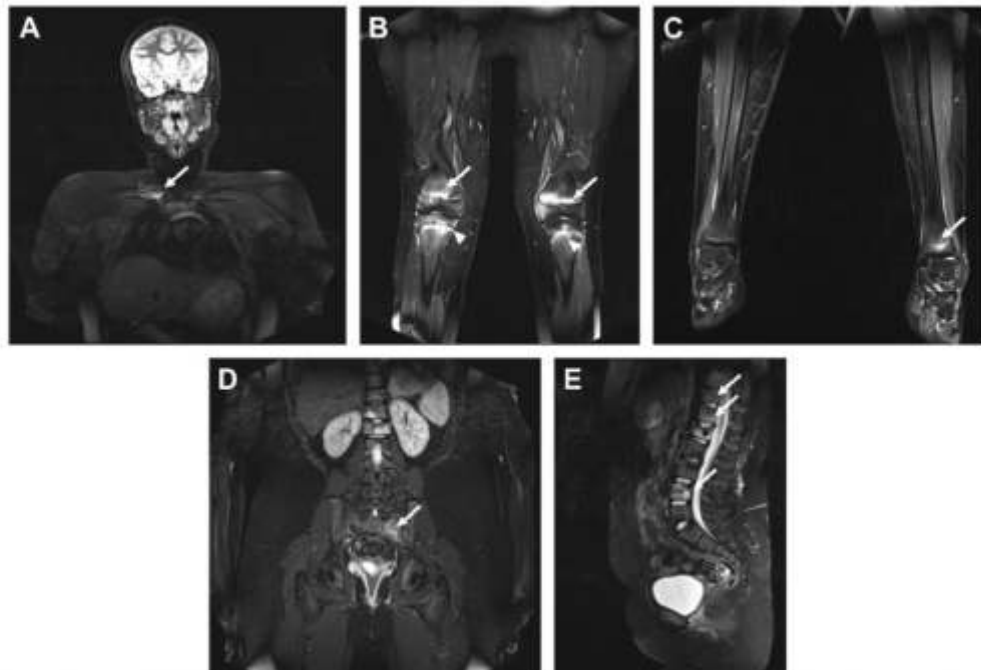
Whole body MRI in a 12-year-old girl with chronic recurrent multifocal osteomyelitis (CRMO). T2 TIRM images show bone marrow oedema of the sternal end of the right clavicle with oedema of the surrounding tissues (A), bone marrow oedema of the distal femoral epiphysis, proximal tibial epiphysis, and to a minor extent in a knee joint epiphyses bilaterally (B), bone marrow edema in the left distal tibial epiphysis (C), left-sided sacroiliitis (D), and bone marrow oedema of several vertebral bodies of the thoracic and lumbar regions, with a fracture of the L1 vertebral body (E).
